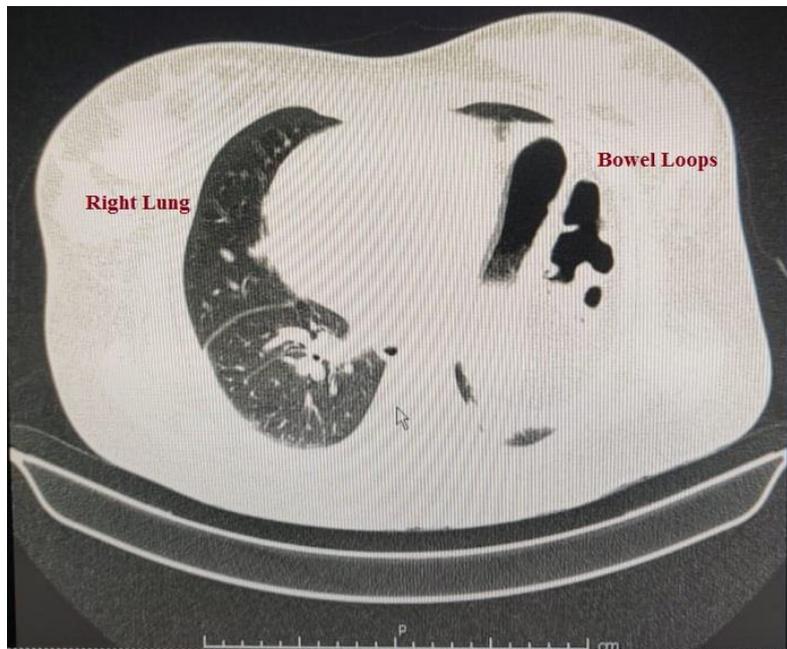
HRCT Shows bowel loops in left hemithorax
